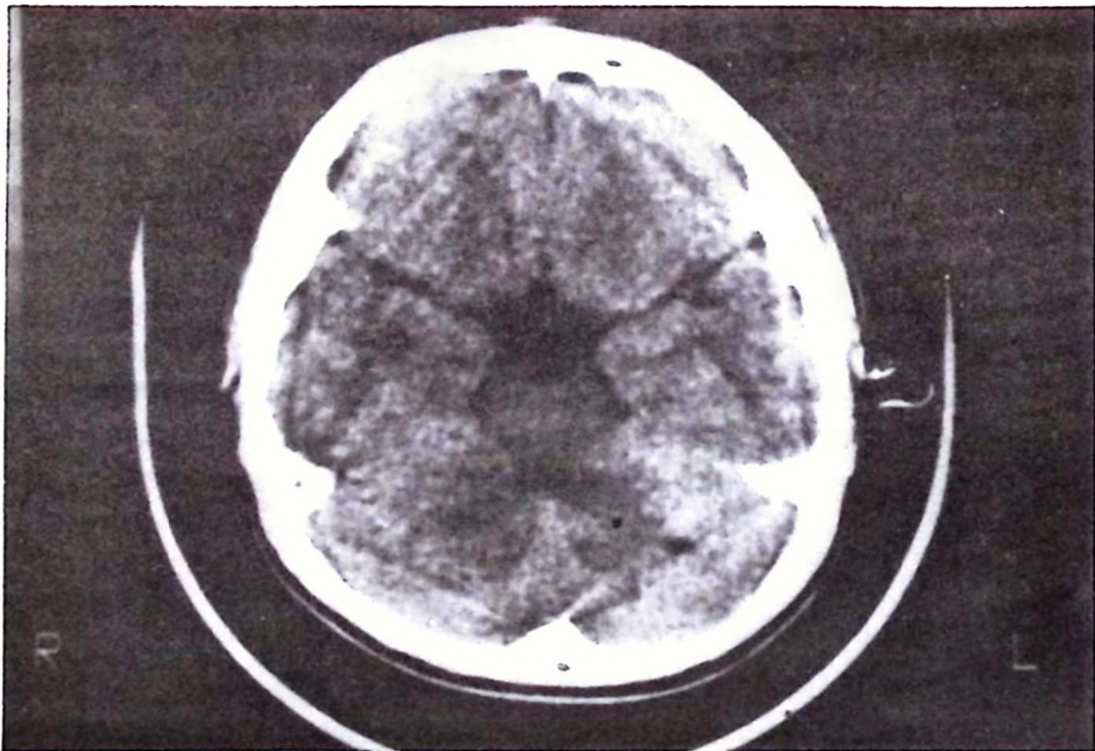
CT demonstrates ill-defined areas of low density in both cerebellar hemispheres.
